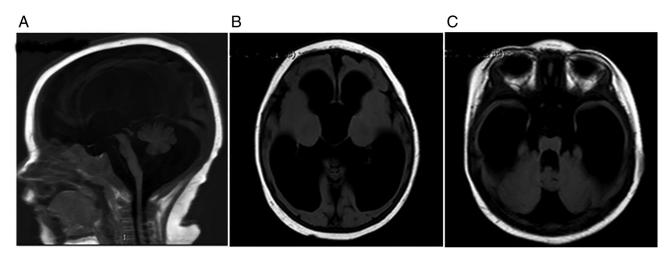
Brain magnetic resonance imaging result of the patient at 4 months of age. (A) Sagittal T1-weighted image showing dilation in the cisterna magna and vallecula of the cerebellum, as well as atrophy in bilateral cerebellar hemispheres. Hypoplasia in the brain stem could also be observed. (B and C) Axial T1-weighted image revealed dilated ventricular system and the loss of white matter in cerebral hemispheres. Enlarged sulci could also be observed.
